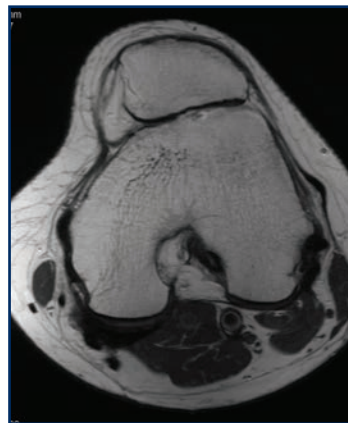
Axial MRI depicting end-stage patellofemoral arthritis in the setting of trochlear dysplasia.
